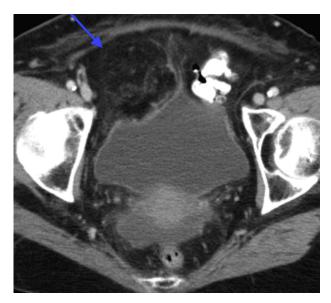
Changes of early fat necrosis (blue arrow) on the first post-operative CT scan 29/7/2013 with mass effect upon the urinary bladder.
